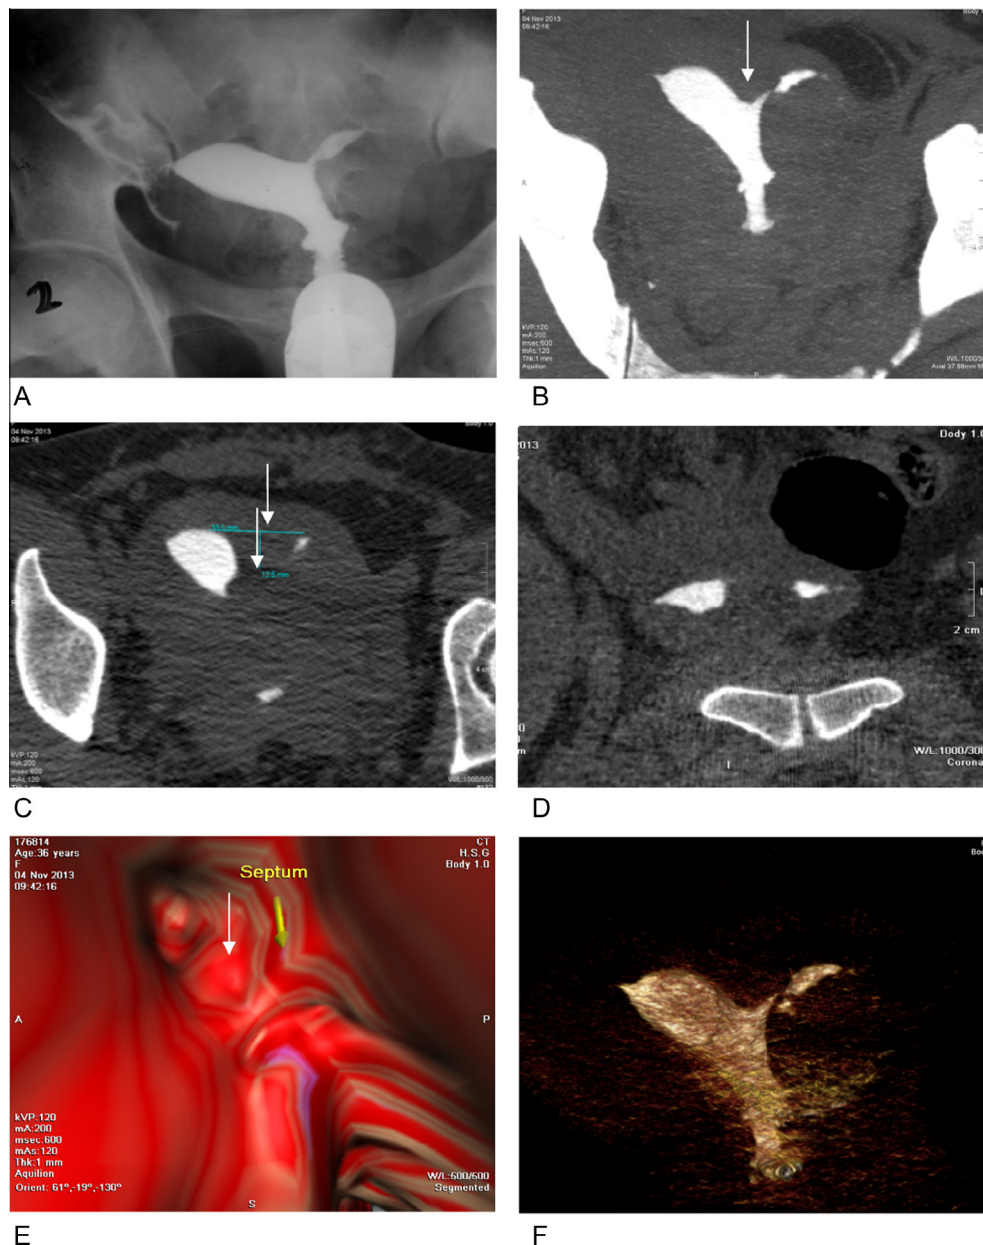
Incomplete uterine septum with left tubal block. (A) The X-ray HSG revealed bicornuate uterus instead of incomplete uterine septum, there is left tubal block. The MDCT VHS revealed incomplete uterine septum (arrow) measuring 3.3×13 mm (transverse and AP diameter), and bilateral tubal block. (B and C) Maximum intensity projections. (D) Axial cut showing uterine septum (arrow). (E) Virtual endoscopic views (F) Volume rendering reconstruction.
